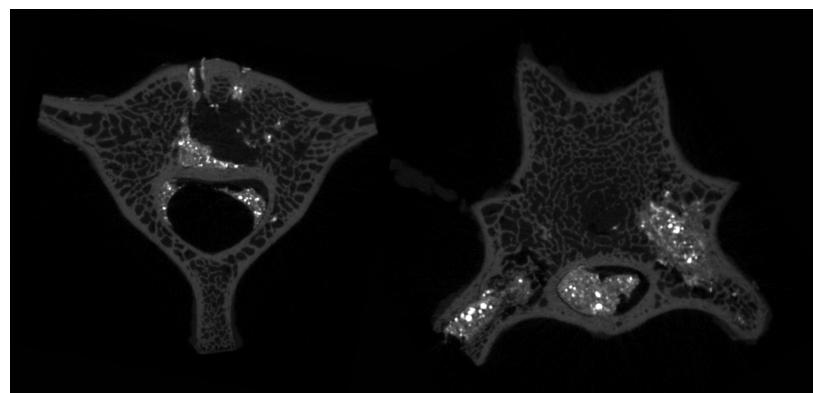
μ CT scans of two vertebra, showing the cement leaking into the spinal canal and out of the vascular channels and the vertebral surface.
